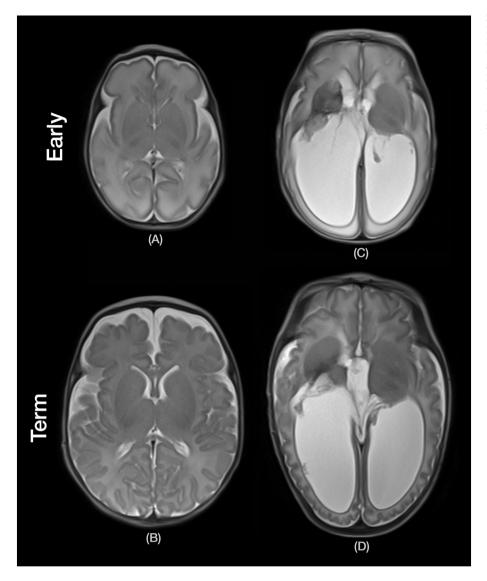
T2 HASTE axial images. On the left: a subject with Early (31 weeks PMA; A) and Term (39 + 6 weeks PMA; B) MRI both scored as normal; and normal motor and cognitive outcomes at 12 months corrected age. On the right: a subject with post-hemorrhagic enlargement of lateral and III ventricles with capsular-thalamic right venous infarction. Early MRI (33 + 3 weeks PMA; C) and Term MRI (40 + 3 weeks PMA; D) for this infant scored in the severe brain abnormality range, and this infant has been diagnosed with cerebral palsy (left hemiplegia).
